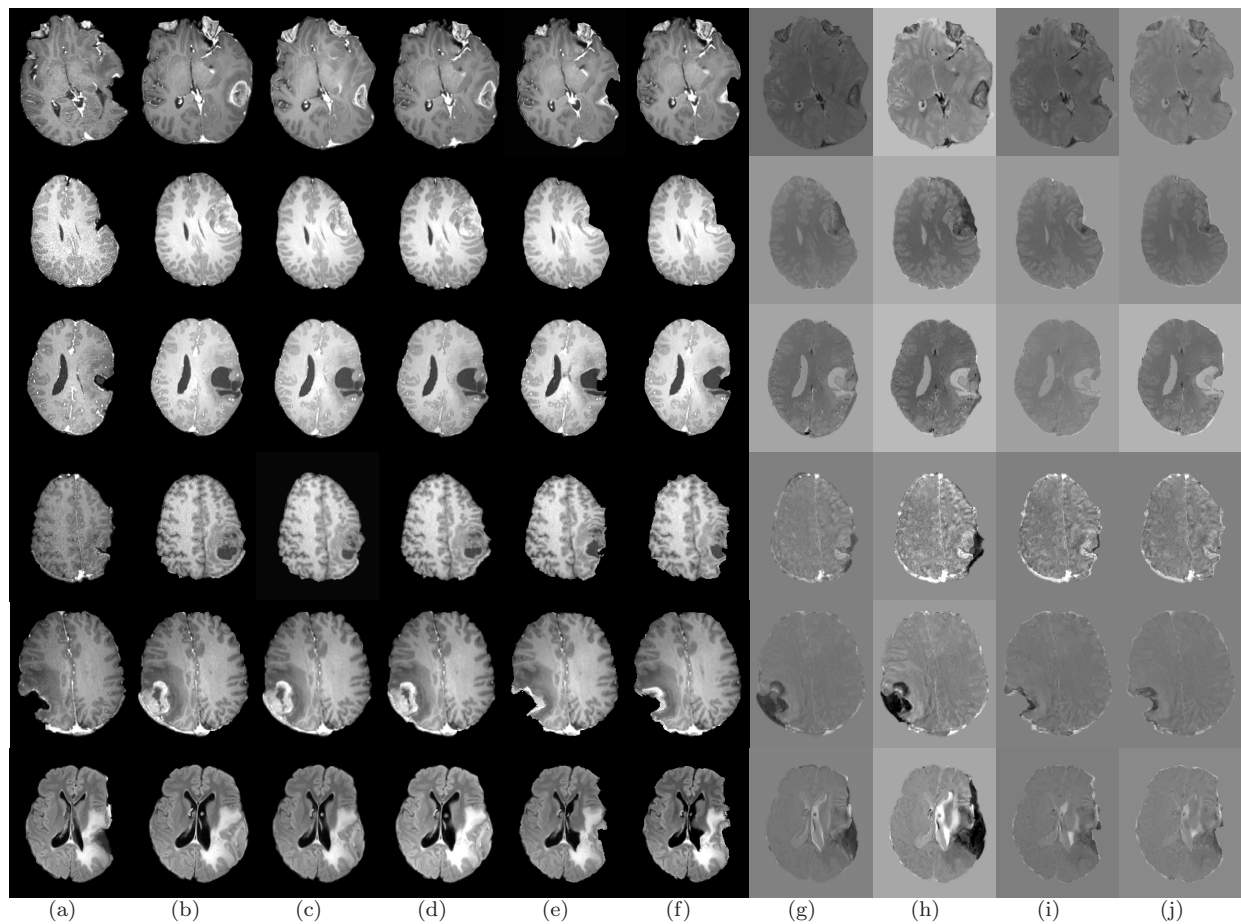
Qualitative results for the Rigid, BSpline, PBNRR, APBNRR, and PAPBNRR registration methods. Each row represents a single case. From top to bottom row: case 1-6. From left to right column: (a) intra-op MRI; (b) rigid pre-op MRI; (c) non-rigid BSpline pre-op MRI; (d) non-rigid PBNRR pre-op MRI; (e): non-rigid APBNRR pre-op MRI; (f): non-rigid PAPBNRR pre-op MRI; (g): (c) subtracted from (a); (h): (d) subtracted from (a); (i): (e) subtracted from (a); (j): (f) subtracted from (a).
